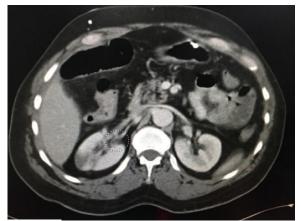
CT scan showing right renal artery distal thrombosis and partial right renal infarction
